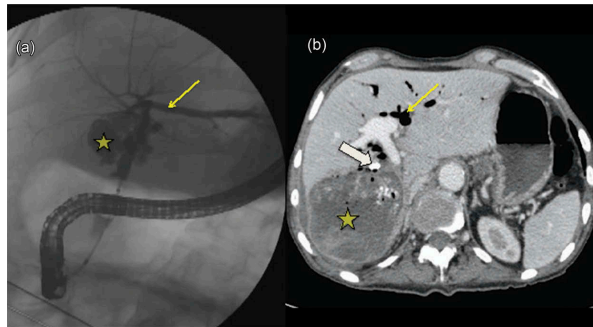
Imaging features of alveolar echinococcosis (AE) per endoscopic management. Cholangiography: communication between the parasitic necrosis (star) and bile ducts (small arrow) (a). Computed tomography: control of the drainage of the bile duct (small arrow: pneumobilia) with 2 plastic stents (large arrow) in a patient with AE and large parasitic necrosis (star) (b).
